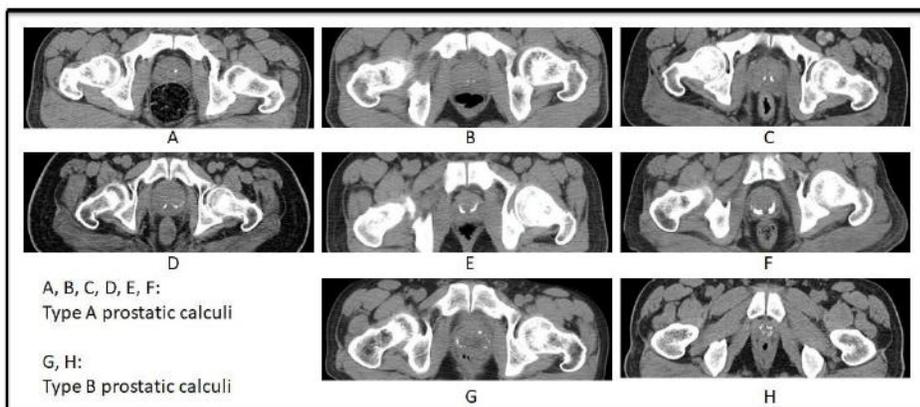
Classification of Prostatic Calculi Based on CT images
